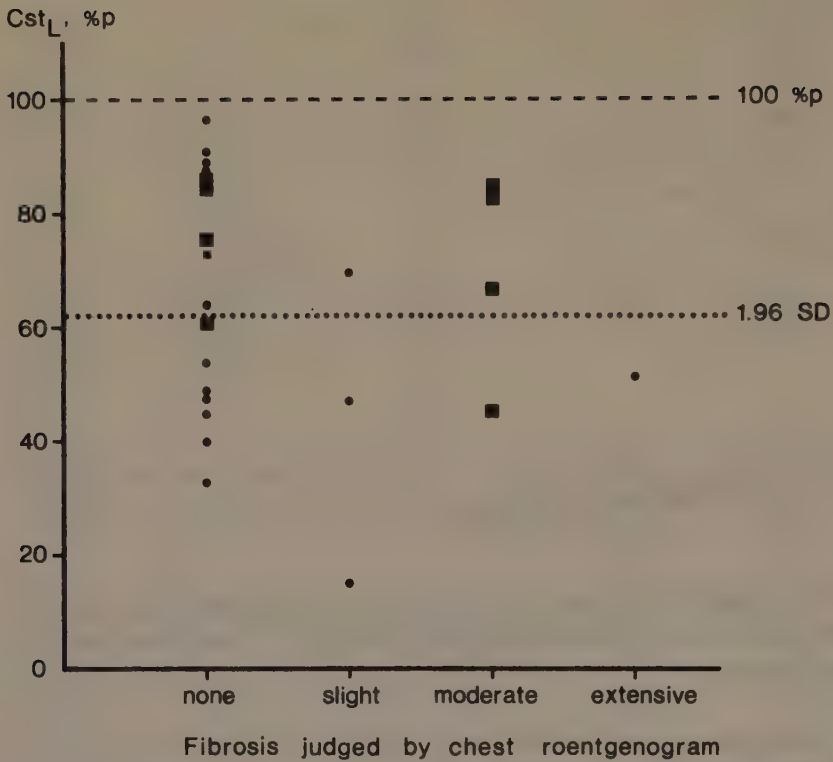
The relationship between Cst_L %p and lung fibrosis judged by roentgenogram. The evaluations slight, moderate or extensive fibrosis refer to the interstitial changes in the lung parenchyma.
